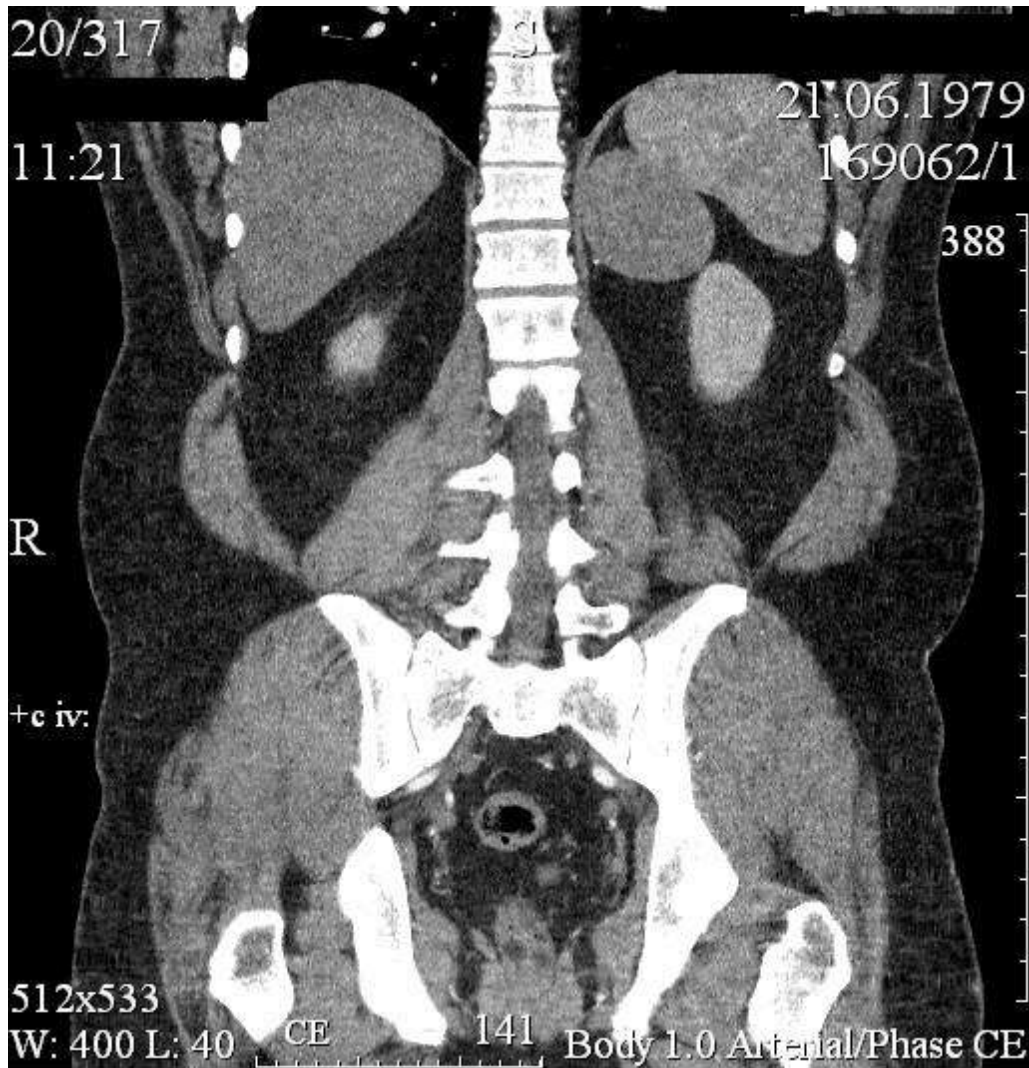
Adenoma of the left adrenal gland. Computed tomography, arterial phase of the study.
